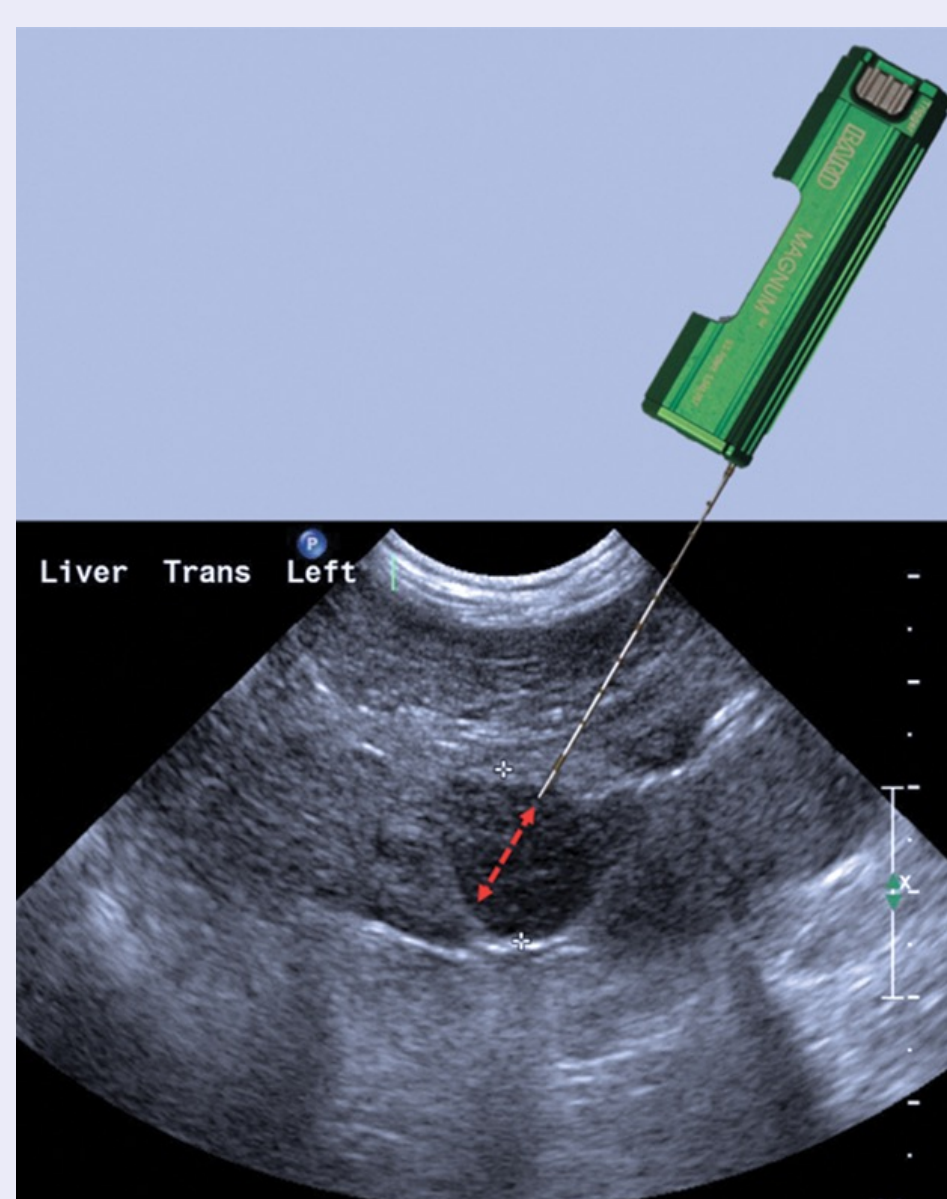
Ultrasound Guided Percutaneous Liver Biopsy. Source: (Kumar 2019)
